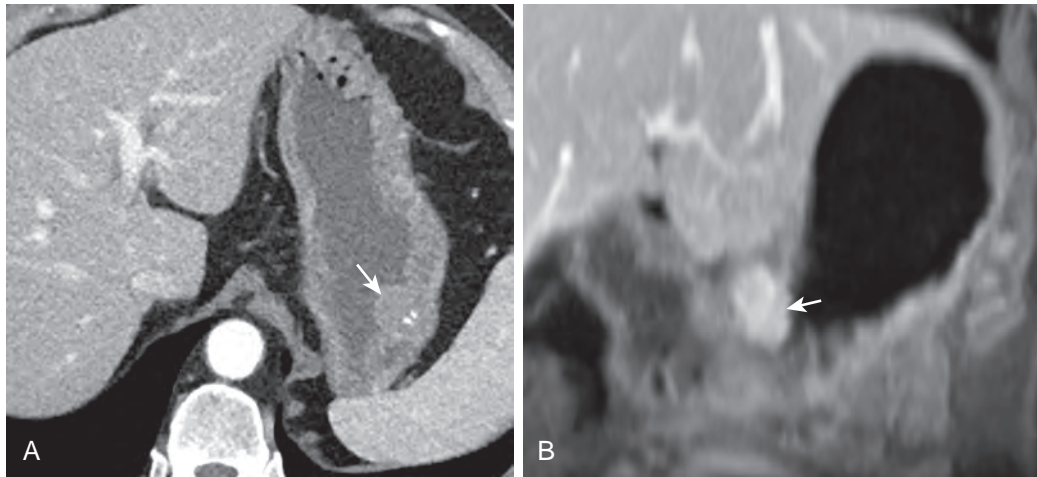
Small, low-grade gastrointestinal stromal tumors on CT and MRI. A. A low-grade epithelioid lesion is seen on CT as a small (2 cm), well-defined mass (arrow) on the posterior wall of the gastric fundus. Note discrete areas of punctate calcification, an occasional finding in these tumors. B. Another low-grade lesion is seen on a 3D gadolinium radial VIBE (volumetric interpolated breath-hold examination) image at MRI as a small (3 cm), homogeneous intramural mass (arrow) at the level of the gastric incisura.
